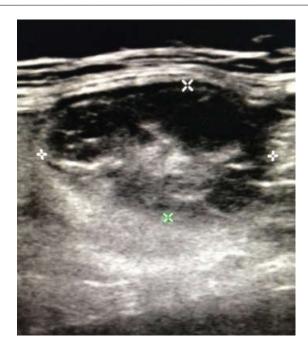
Sonographic View of Ascending ColonApendagitis
